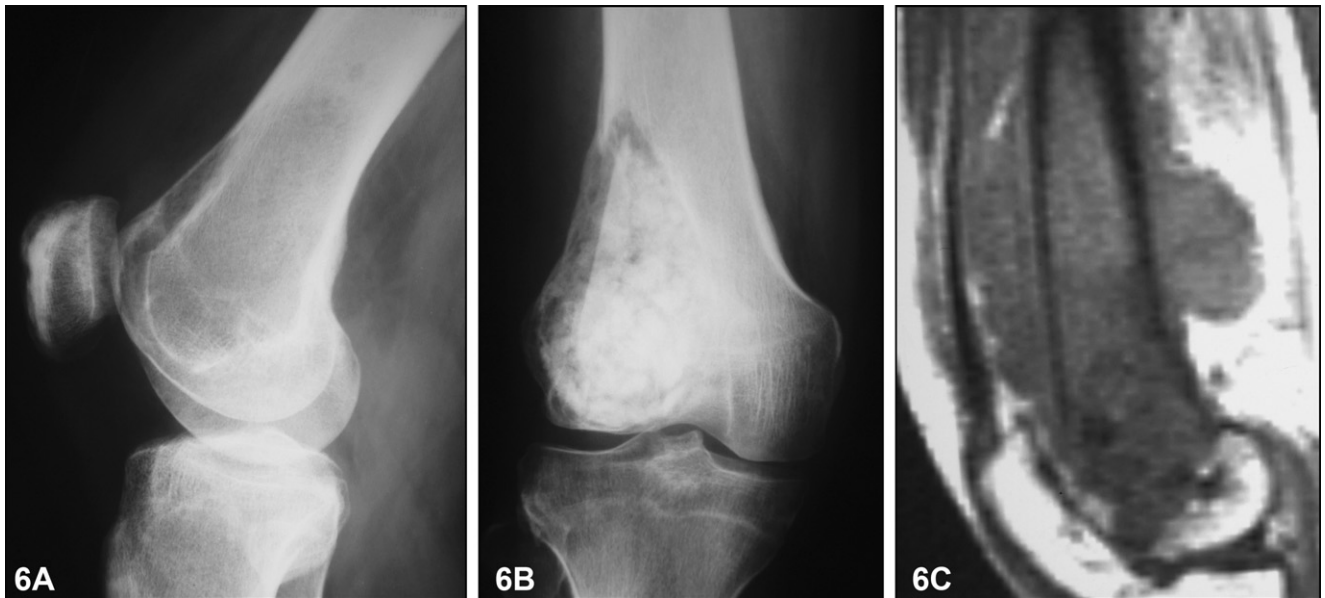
Case 10: (A) Giant cell tumor, August 1969: on the sagittal radiograph, well limited lytic lesion. (B) After curettage and grafting with allograft bone, December 1969. (C) December 1996, sagittal T1W MR image: massive medullary and soft tissue involvement: osteosarcoma.
